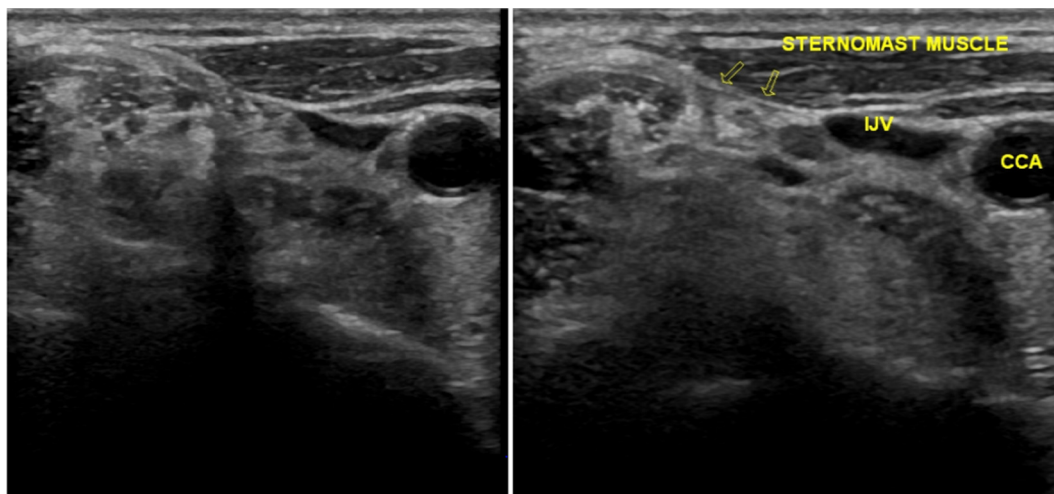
Ultrasound guided superficial cervical plexus block: arrows pointing at sternocleidomastoid-scalene inter muscular plane where local anesthetic is injected (right side of the neck). IJV: internal jugular vein, CCA: common carotid artery.
